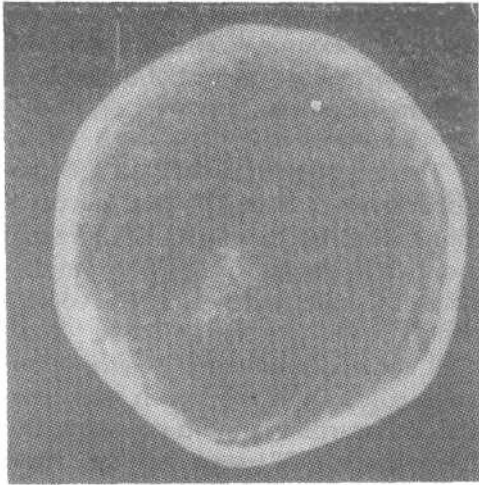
CT scan showing absence of both hemispheres along with absence of falx and olfactory bulbs.
